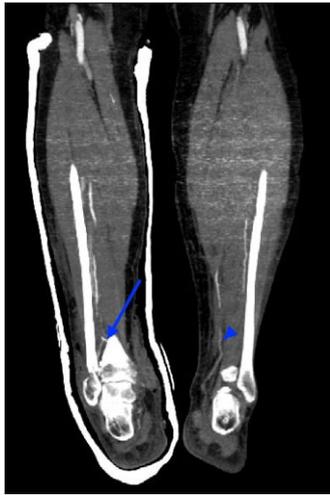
CTA sagittal view: \blacktriangledown aberrant vessel from the peroneal artery; \blacktriangleright normal PTA (contralateral leg).
